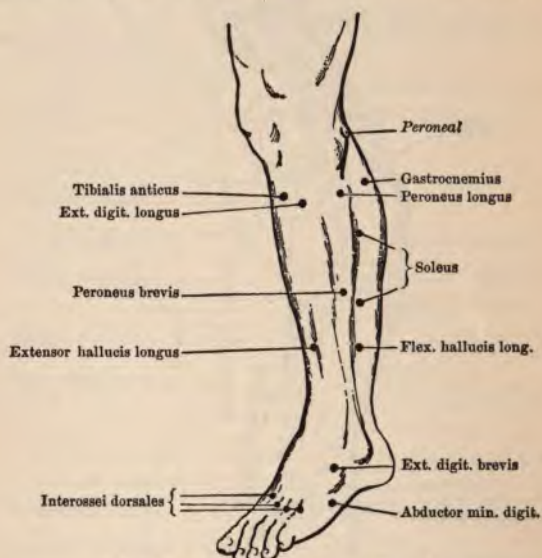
OUTER ASPECT OF LEFT LEG.
